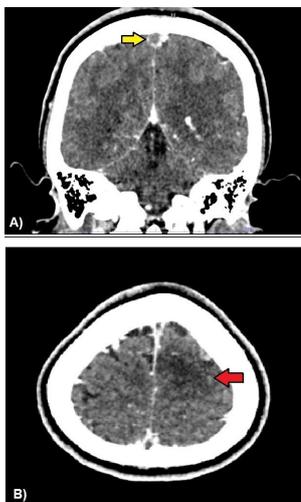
(A) and (B): Computed tomography angiogram of patient's brain. Note the filling defect over the superior sagittal sinus (yellow arrow), suggestive of cerebral venous sinus thrombosis, with acute venous infarct at the left frontal lobe (red arrow).
